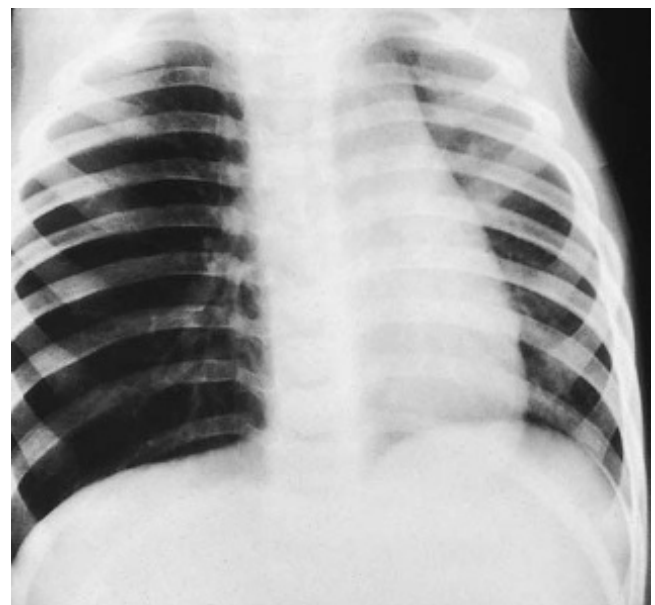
Chest X-ray showing hyperinflation of the right lung due to a foreign body in the right main stem bronchus.
